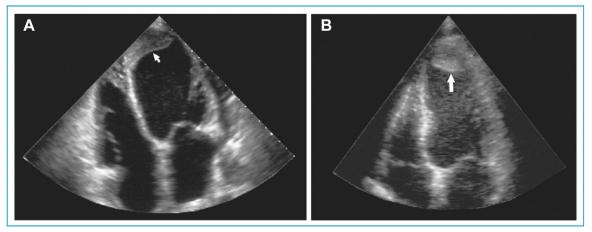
Left ventricular thrombi in the apical 4-chamber view from 2 different patients. An organized and nonmobile thrombus is detected in the first patient (arrow in A), and a mobile thrombus (arrow in B) is seen in the second patient in a region of akinesia and apical aneurysm. The latter patient suffered a stroke within hours of this echocardiographic examination. Reproduced, with permission, from Diaz et al. [93].
